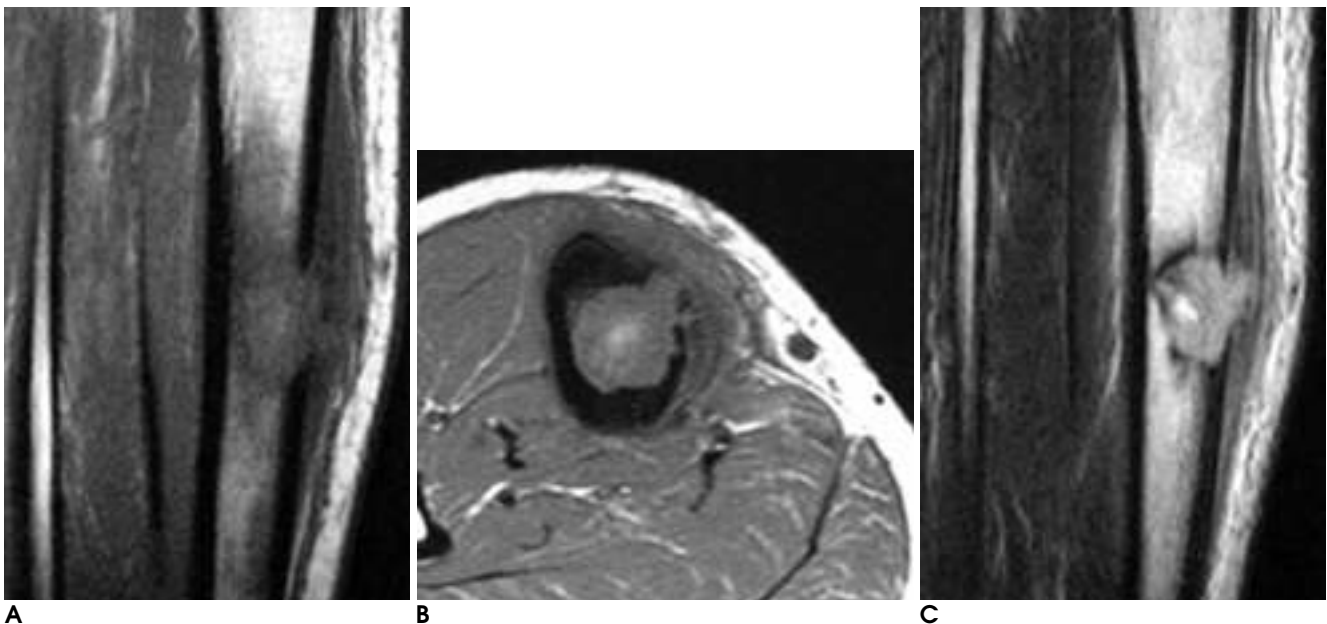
A, B, C. T1-weighted (566/16) oblique coronal and axial images show ill-defined low signal intensity lesion replacing normal hematopoietic marrow and peritumoral patchy areas of low signal intensity, which are increased in signal intensity on FSE T2-weighted (2800/63) coronal image.
